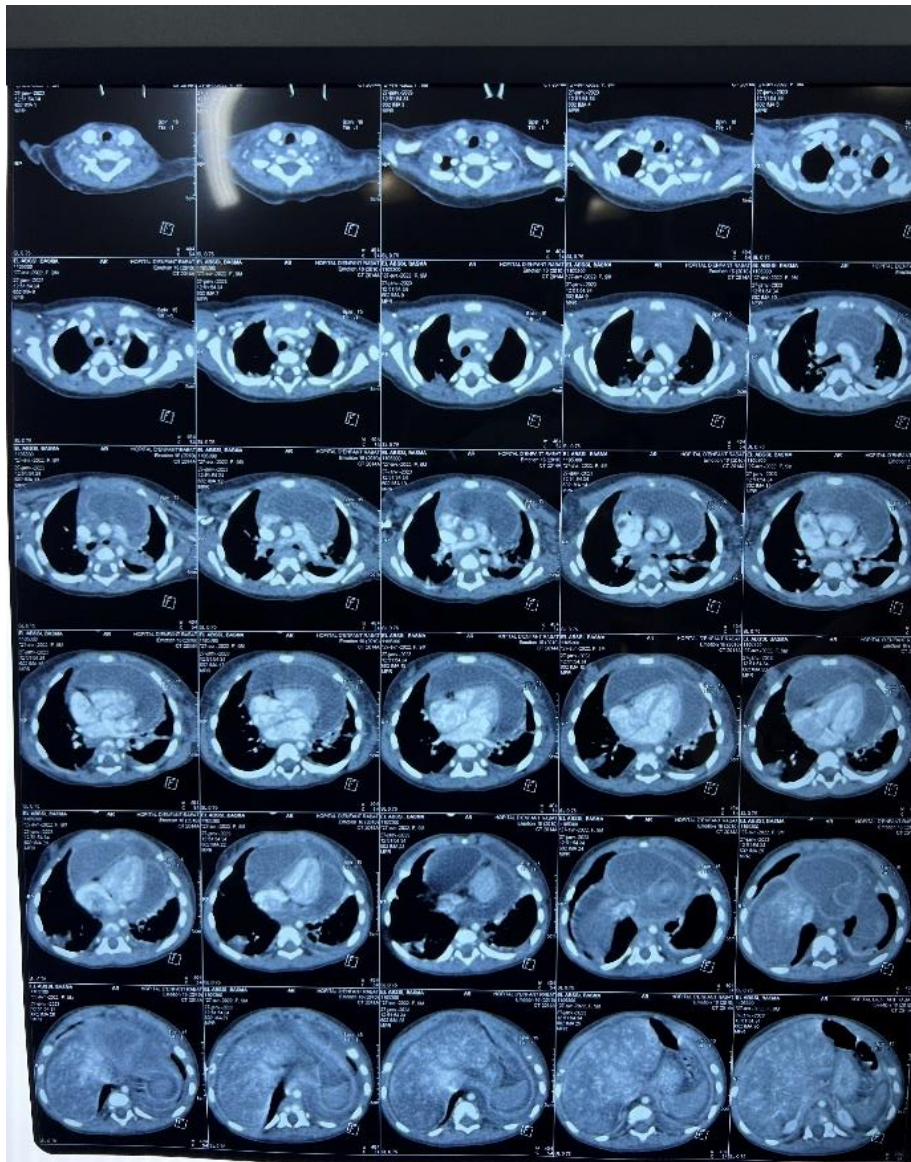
Image of thoracic CT scan showing circumferential pericardial effusion
